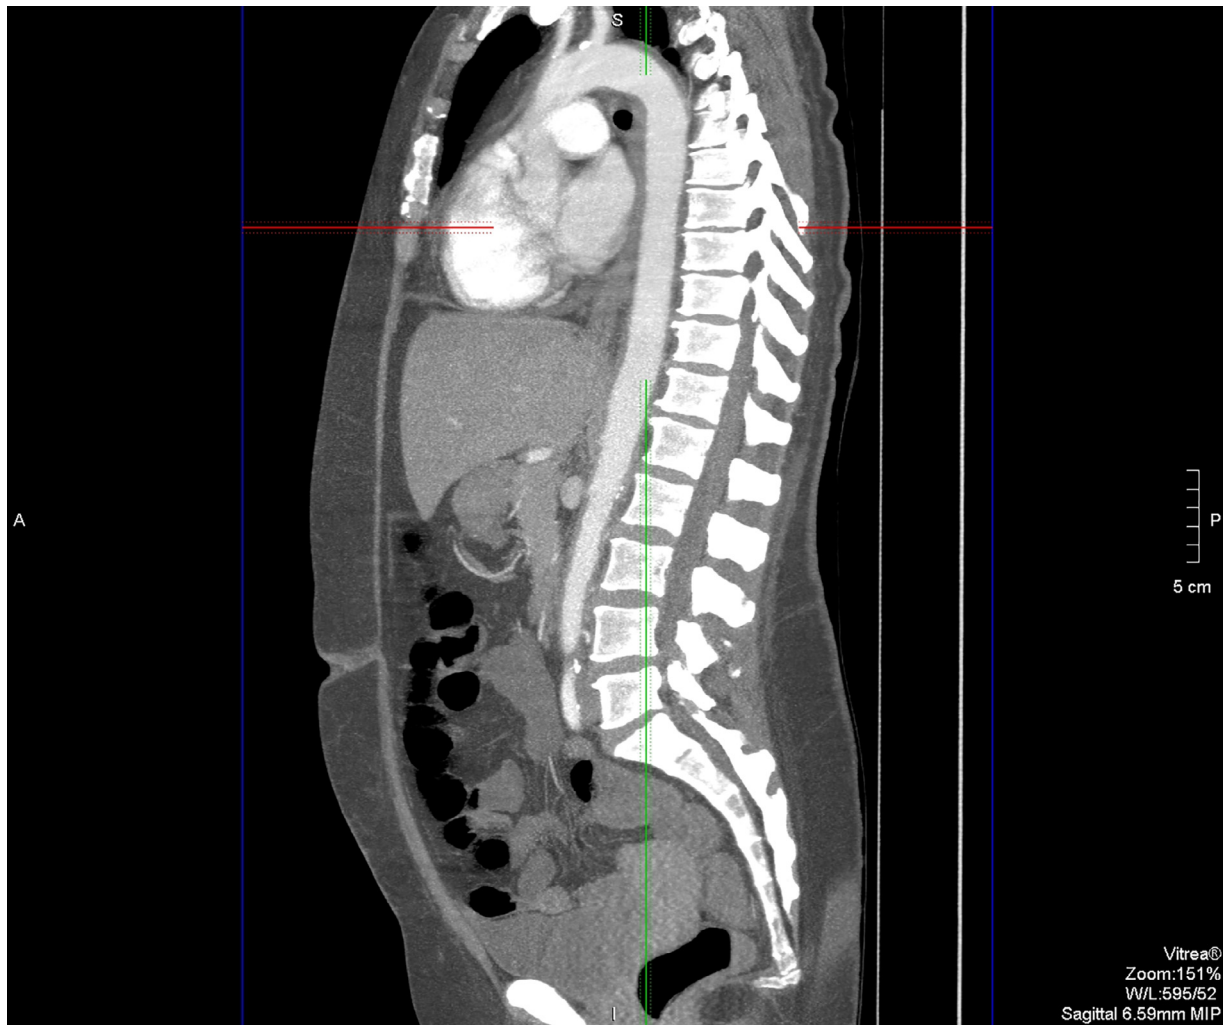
Sagittal section of a CT of the aorta with intravenous contrast, showing subtle thickening of the wall of the aorta throughout.
